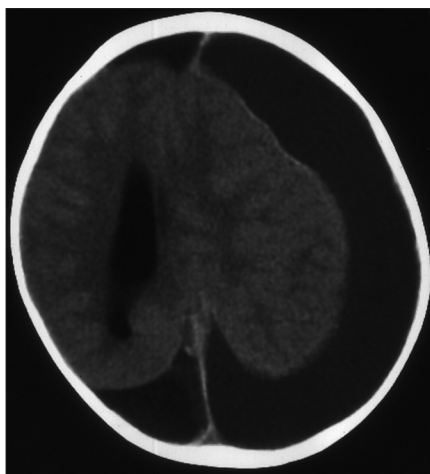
Leukemic leukocytosis in a two-year-old boy who presented with vomiting and progressive lethargy. Hyperleukocytosis (white blood cell count of 157,000/mm³) and thrombocytopenia (platelet count of 48,000/mm³) were significant laboratory parameters. The axial computed tomographic (CT) scan reveals a fronto-occipital subdural hematoma
